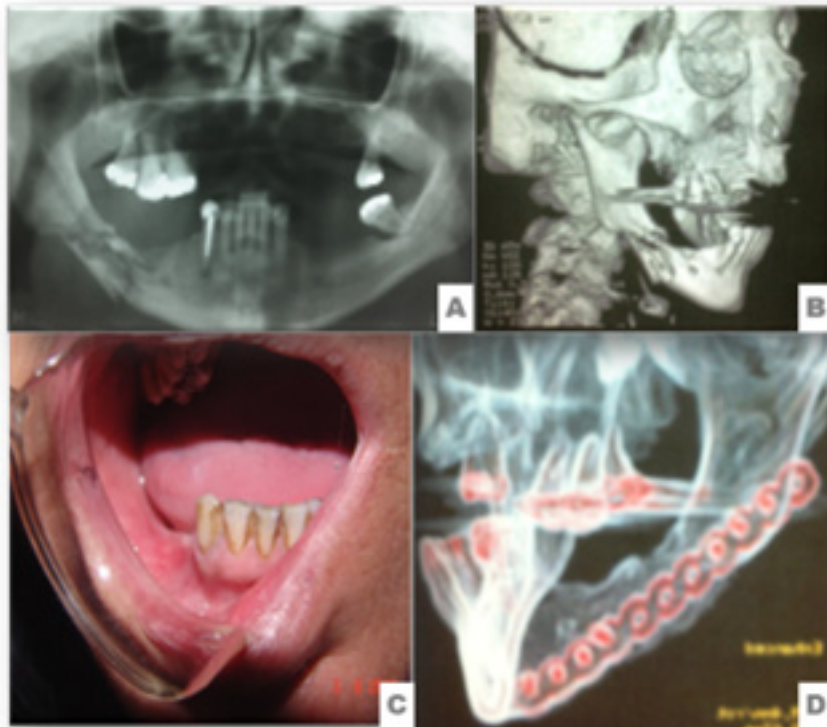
Panoramic radiography (A) and 3D computerized tomography (B) showing the fracture in the region of the right mandibular body. At 12 months post-graft surgery, we observed healing of the mandibular ridge in intraoral view (C). In the oblique lateral view of the computerized tomography, the adaptation of the 2.4 macroplate and integration of the autogenous graft are evident.
